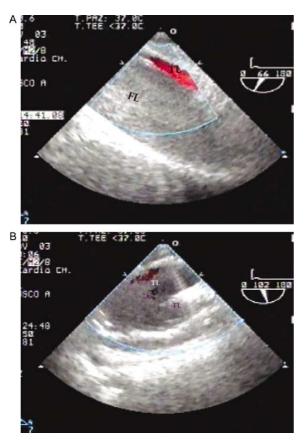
(A) and (B) MDCT images after stent-graft treatment: complete thrombosis of the false lumen and aortic remodelling with true lumen expansion and FL shrinkage. (A) Transesophageal echocardiography image of a patient with acute type B dissection and malperfusion syndrome. The false lumen is enlarged and compresses the true lumen. There is a slow flow in both true lumen and false lumen (smoking effect). (B) After stent deployment: immediate normalization of flow with true lumen expansion.
